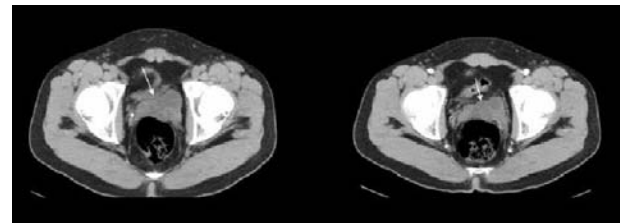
CT scan confirmed the presence of cystic structures in the topography of the left seminal vesicle
